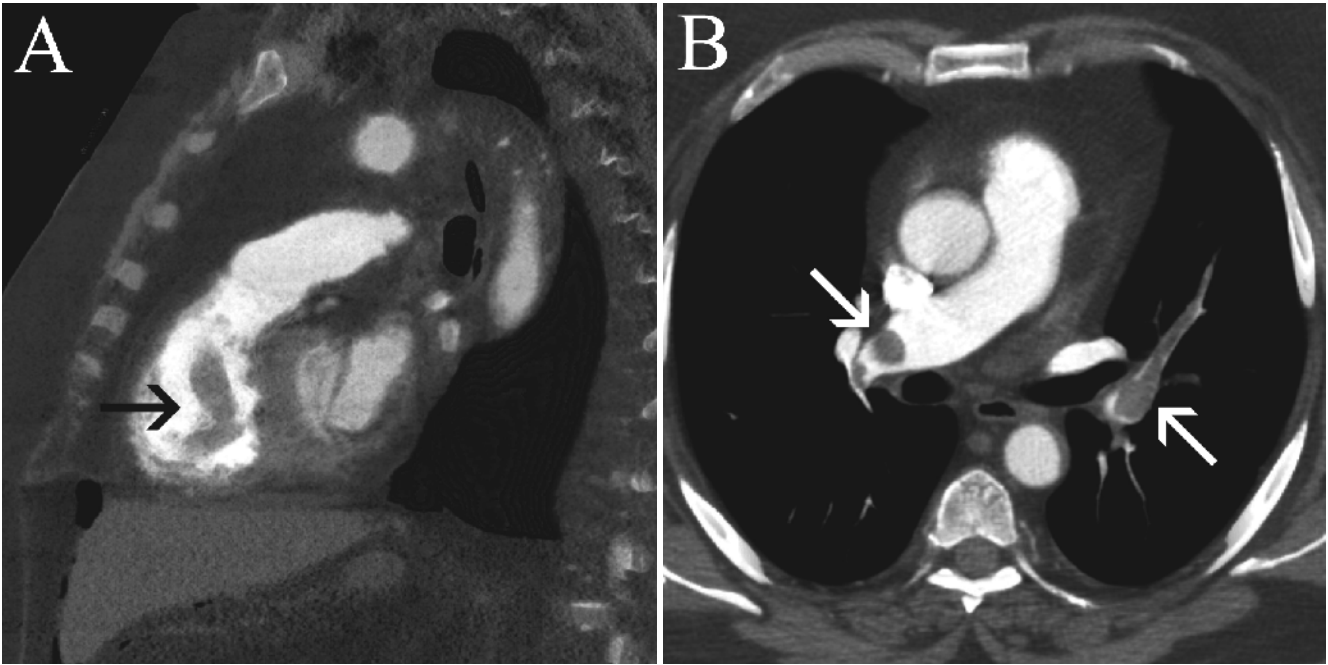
Twenty-two-year-old female with a primary pericardial primitive neuroectodermal tumor. Images obtained are obtained as part of a postcontrast nongated CT scan of the chest. Transverse and oblique four-chamber views are shown (a–d). In this case, the tumor was causing
